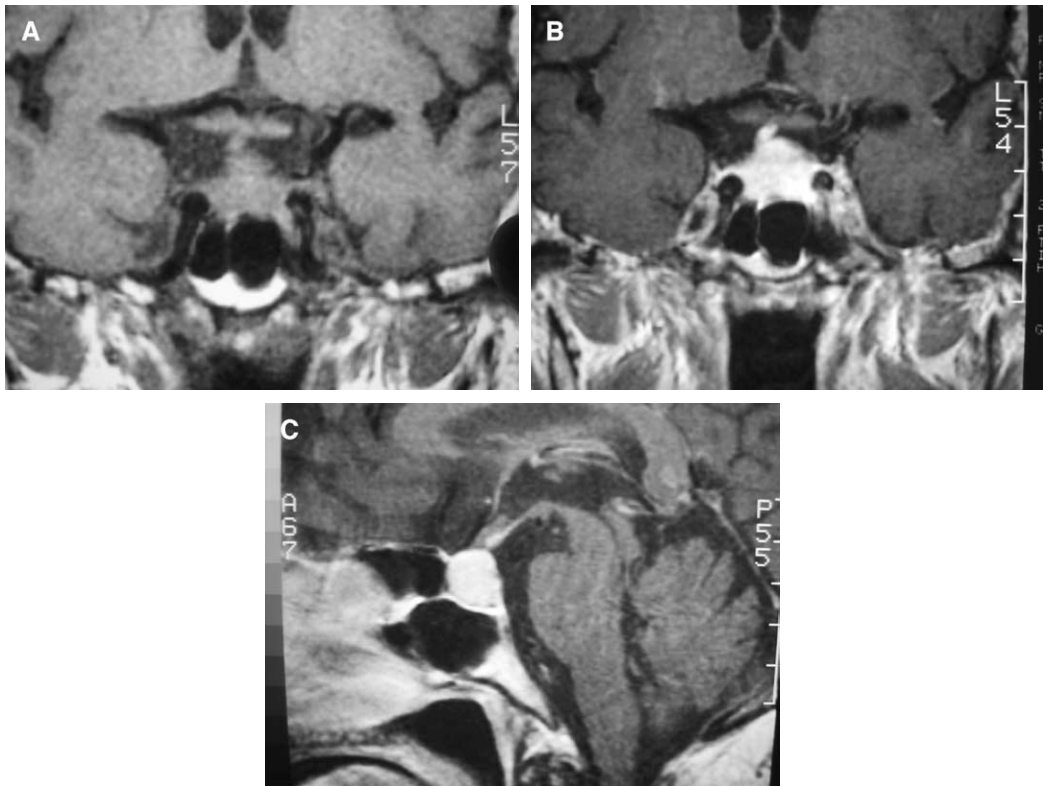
Lymphocytic adenohypophysitis. (A) Coronal T1-weighted image shows a sellar suprasellar mass, mimicking a pituitary adenoma. (B) Coronal postcontrast T1-weighted image shows enhancement of enlarged pituitary gland and thickened pituitary stalk. (C) Sagittal postcontrast T1-weighted image again demonstrates enhancement of the enlarged pituitary and thickened stalk.
